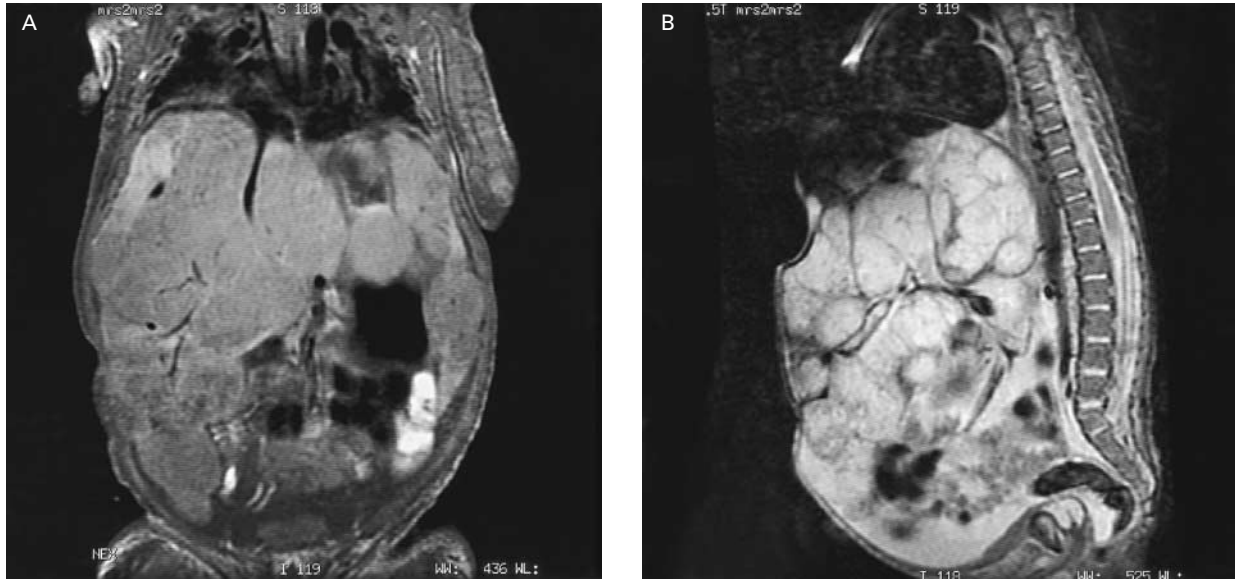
Frontal (Panel A) and Lateral (Panel B) Magnetic Resonance Images of the Abdomen of an Infant with Multiple Hepatic Hemangiomas and Hypothyroidism.
